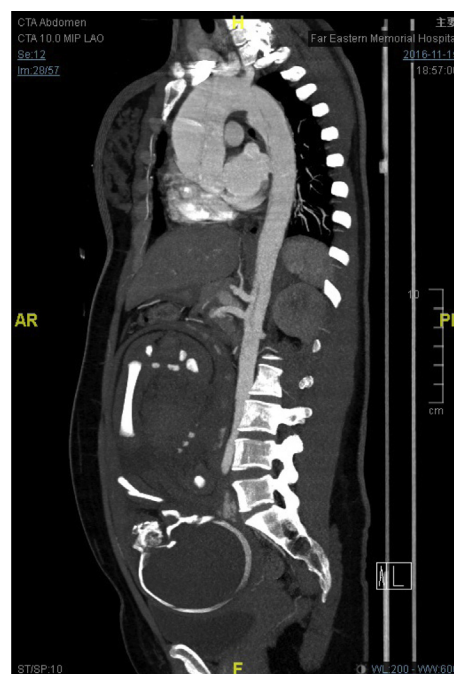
Computed tomography demonstrates type A aortic dissection in ascending aorta (lateral view).
